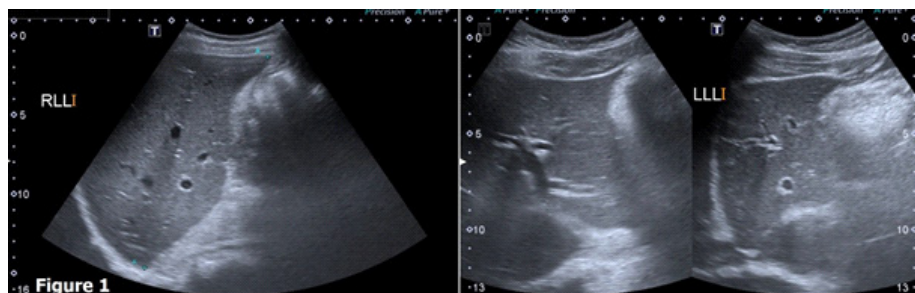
Ultrasound of the hepatobiliary system which shows no focal lesion, and normal liver size and echogenicity in both right and left lobe.
